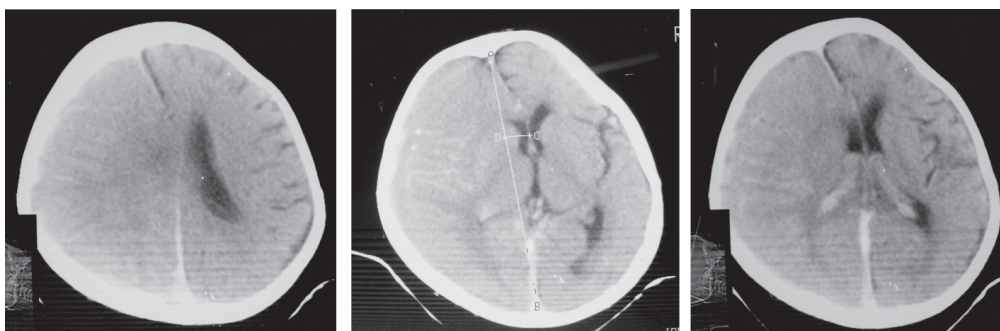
Head CT scan on May 1st 2006 showing chronic subdural and subarachnoid bleeding on the left side, with narrowing of the sulci, compressing the adjacent temporoparietal lobe to the right causing right deviation of the midline structures
